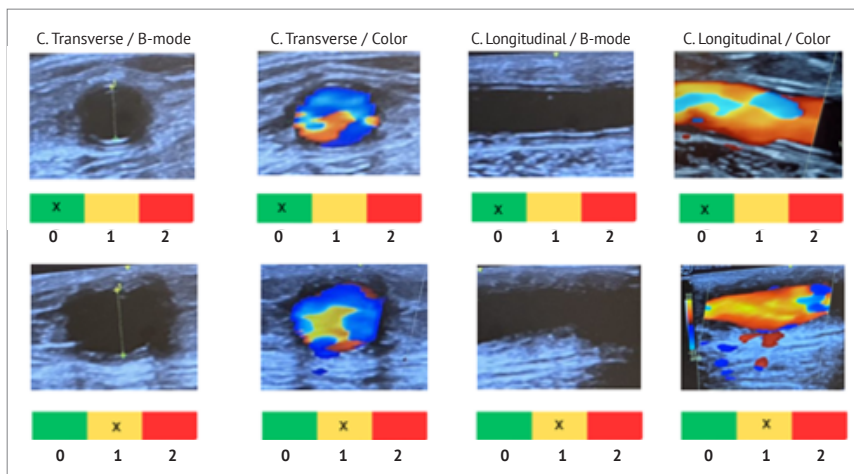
Degree of ultrasound disorganization. Degree of disorganization assessed using a qualitative scale with scores ranging from 0 to 2 (0= absence of disorganization, 1= occasionally disorganized area, 2= disorganized prosthesis), evaluated in both B-mode and color Doppler, in transverse and longitudinal planes.
